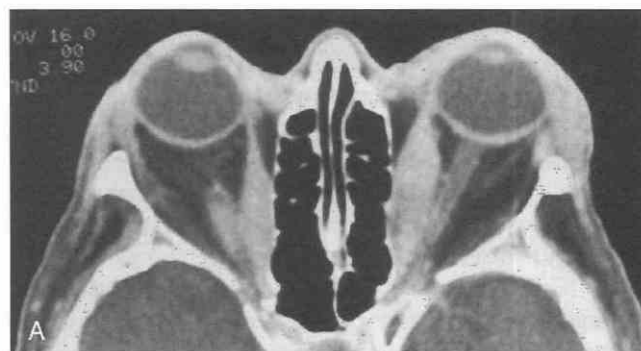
A, Axial contrast-enhanced CT scan shows Graves' ophthalmopathy characterized by enlarged superior, medial, and inferior recti with compromise of the orbital apex. B, Coronal contrast-enhanced CT scan of the same patient shown in A.
